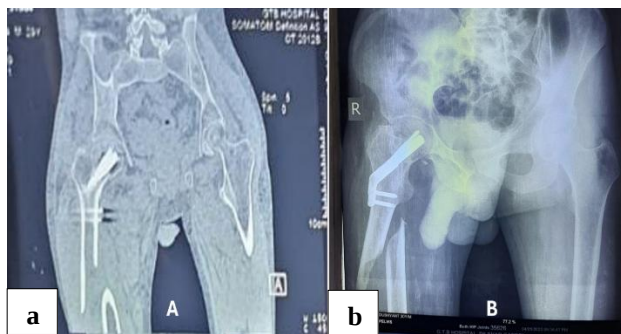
Preoperative radiograph showing femoral shaft fracture and ununited neck with FNS in situ, (a) CT scan, and (b) AP radiograph of pelvis.
